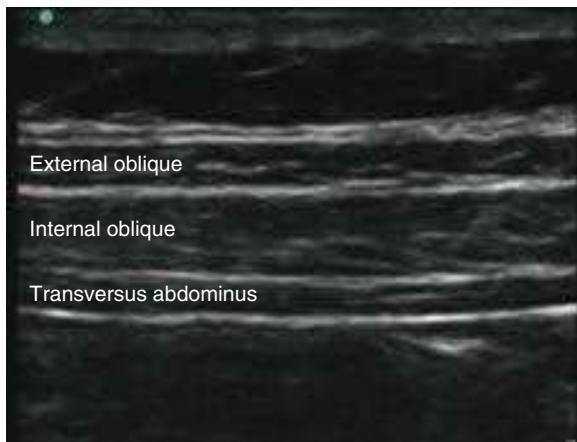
Ultrasound view of external oblique, internal oblique, and transversus abdominis muscles.
